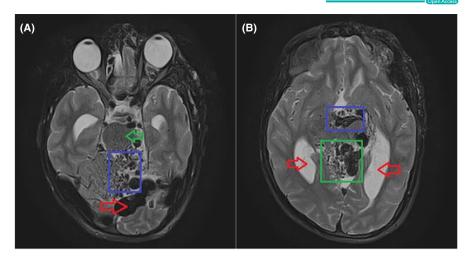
MRI brain and orbits. (A) Axial T2-weighted fat-saturated image demonstrates AVM (hypointense indicating signal void) involving the left cerebellar hemisphere (blue box), causing a mass effect on the pons displacing it to the right (green arrow). A dilated draining vein is also seen (red arrow). (B) Axial T2-weighted fat-saturated image demonstrates AVM involving hypothalamic region (blue box) and basal cisterns (green box), causing obstructive hydrocephalus and leading to dilation of the occipital horns of the lateral ventricles (red arrows).
